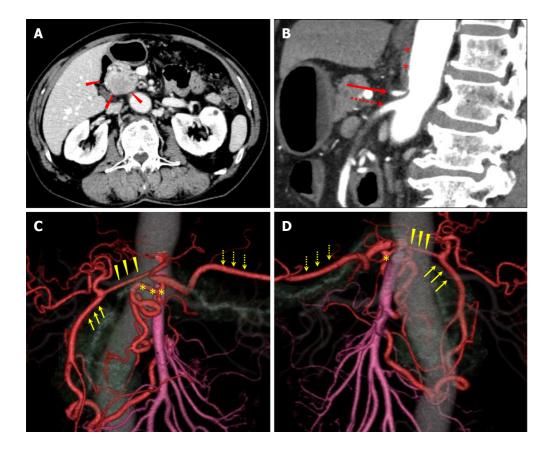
Pre-treatment imaging findings. A: There was a tumor, with poor contrast, in the pancreatic head on computed tomography (CT) imaging. Red arrowheads: the tumor; B and C: Three-dimensional reconstruction imaging showed developed collateral pathways around the pancreatic head. One connected the superior mesenteric artery (SMA) and common hepatic artery (CHA) via the gastroduodenal artery (GDA) and another connected the SMA and splenic artery (SPA) via the dorsal pancreatic artery (DPA); D: The sagittal view of the CT showed celiac axis (CA) stenosis due to compression by MAL which developed caudally. Yellow arrows: GDA; yellow arrowheads: CHA; yellow asterisks: DPA; yellow dotted arrows: SPA; red asterisks: MAL; red arrow: CA; red dotted arrow: SMA.
